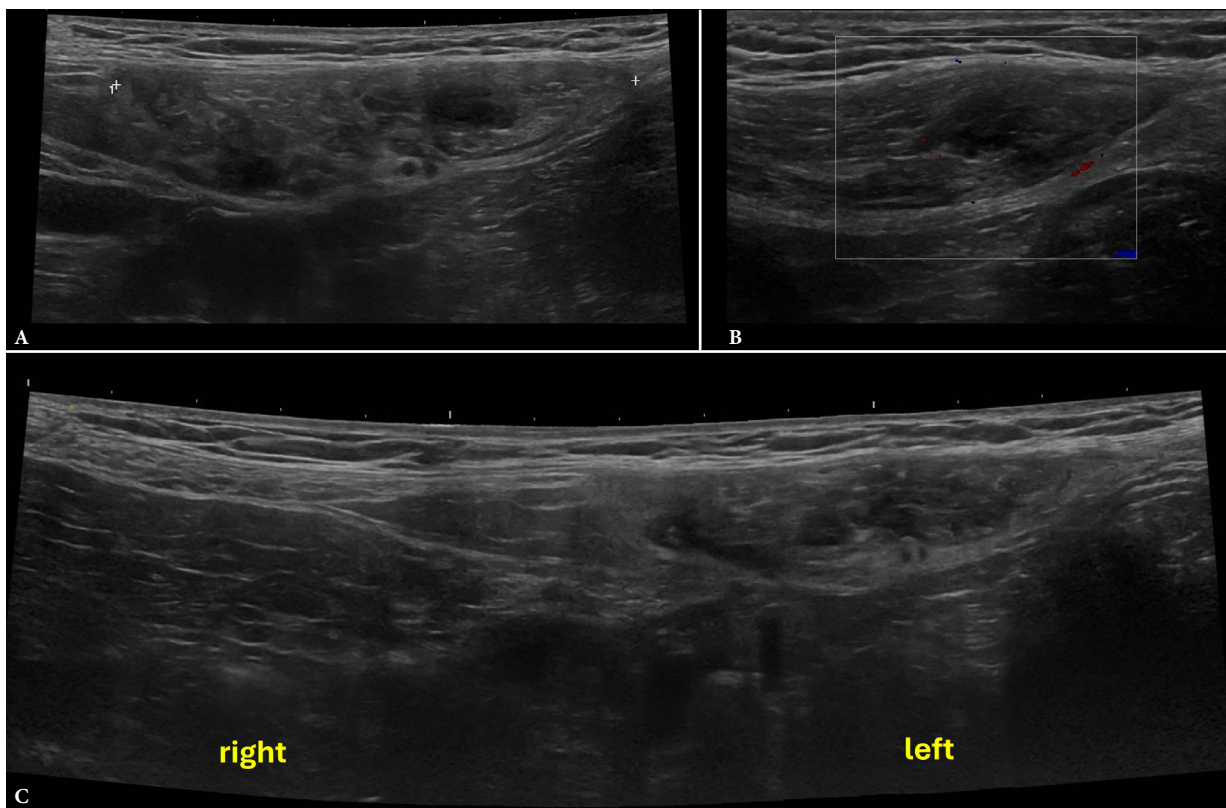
Ultrasound of the left rectus abdominis muscle demonstrating intramuscular thickening (6.8 × 1.6 cm) with heterogeneous hypoechoic areas (A) and no internal flow on CD (B), consistent with an intramuscular hematoma. Comparative imaging (C) confirms asymmetry relative to the contralateral side
